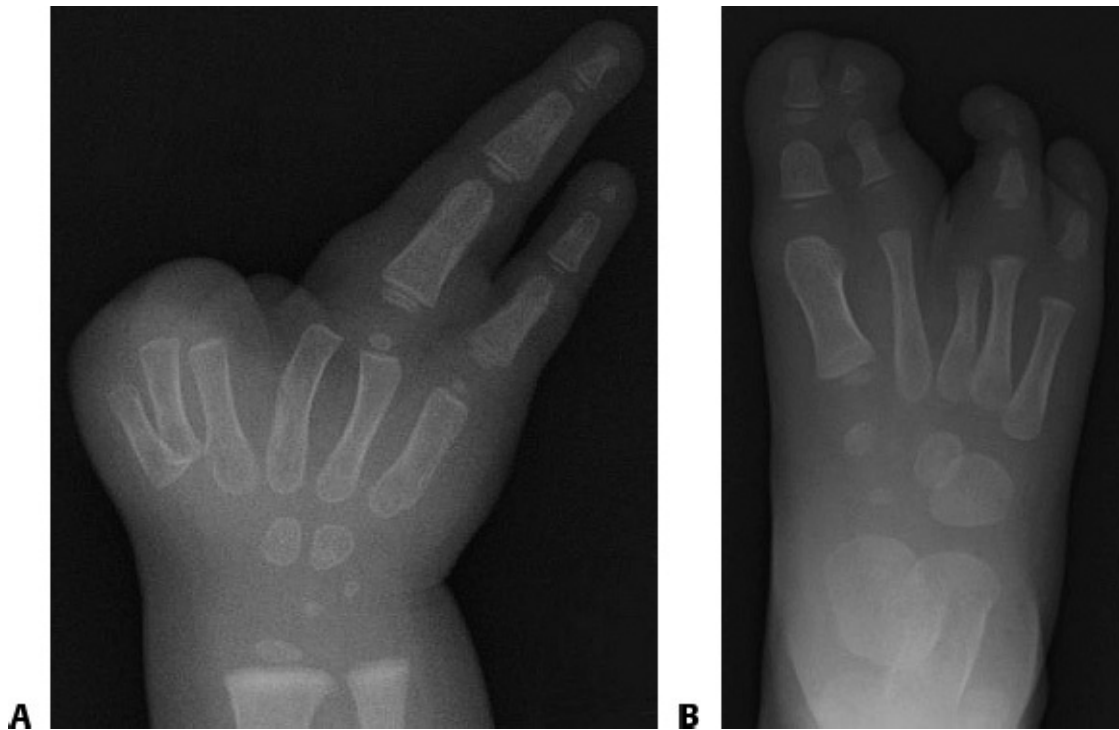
• Radiography of the example case shows three metacarpals on the radial side of the hand (A) and separate skeletal structures in the foot despite webbing of the great and second toes (B). Note that there are only two phalanges in the second toe. The epiphysis of the second metatarsal is not present in this early radiograph, but it is distally located in subsequent films (see TECH FIG 7A), indicating that this is indeed a phylogenetic second toe rather than a preaxial synpolydactyly.
